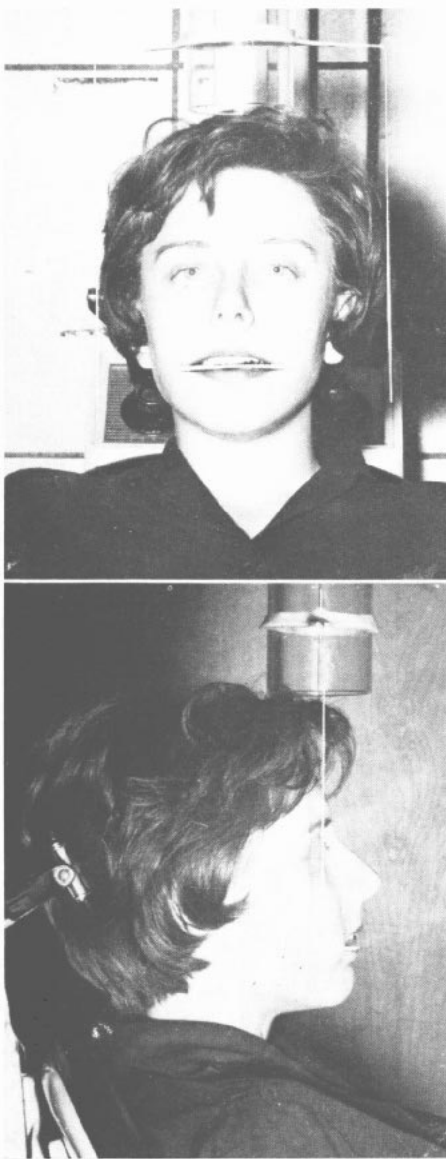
Photograph of device used with long cone to position the patient for x-rays.
